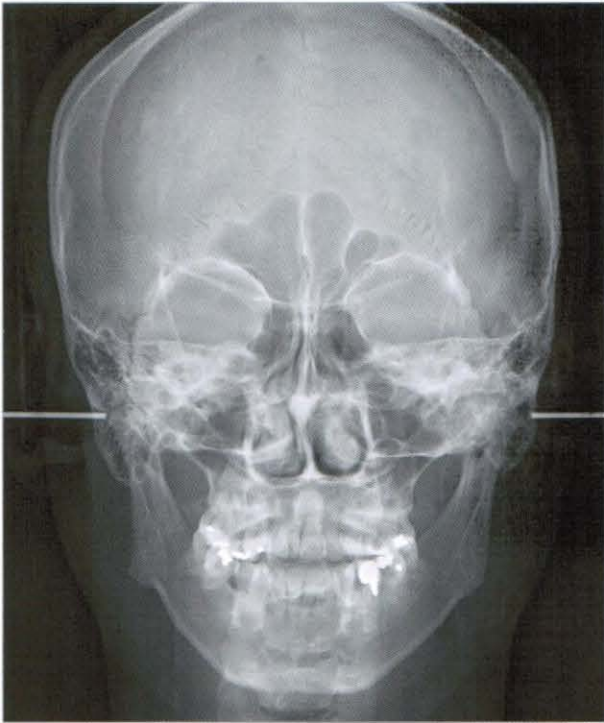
Pre-treatment postero-anterior radiograph (2006, 9.4)
